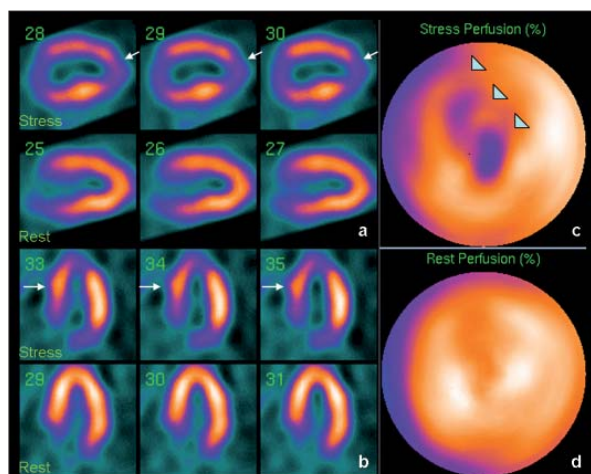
Thallium-201 single photon emission computed tomography myocardial perfusion scintigraphy. *a.* Reduced tracer uptake can be seen in the left ventricular apex during stress (arrows) which returns to normal after reinjection at rest. *b.* There is corresponding reduction of uptake in the septum (arrows) during stress which again returns to normal at rest. The myocardial perfusion scintigraphy data may be arranged as a polar plot (*c* and *d*) with the apex in the centre of the picture and basal myocardium around the edge. The reduced uptake in the apex, septum and anteroseptal region can be seen clearly (*c*, arrowheads) with (*d*) normalization of uptake in the resting images.
